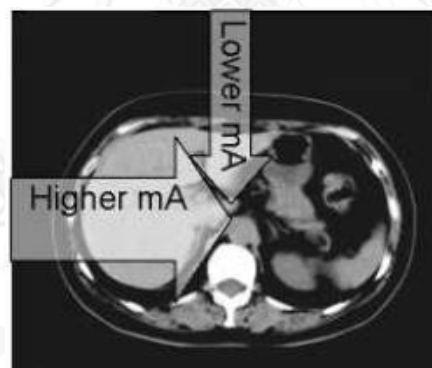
8 Angular modulation of tube current is performed at different projections in the x-y plane within each 360° x-ray tube rotation [2]
